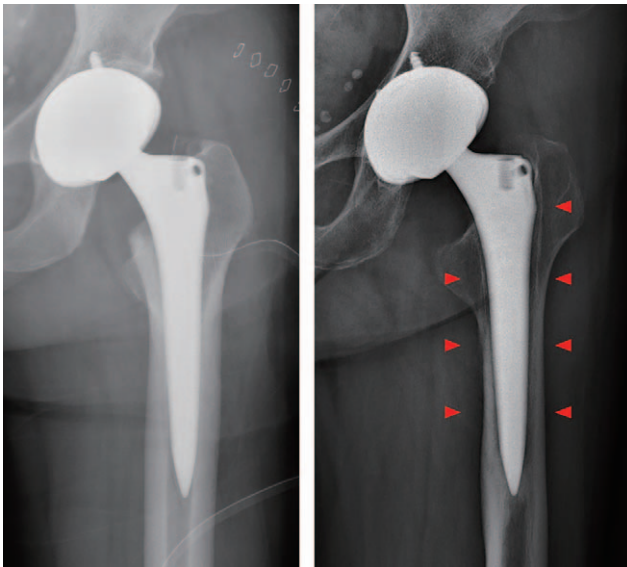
Anteroposterior radiographs showing periprosthetic bone loss (arrows) due to stress shielding at 2 years after total hip arthroplasty.
